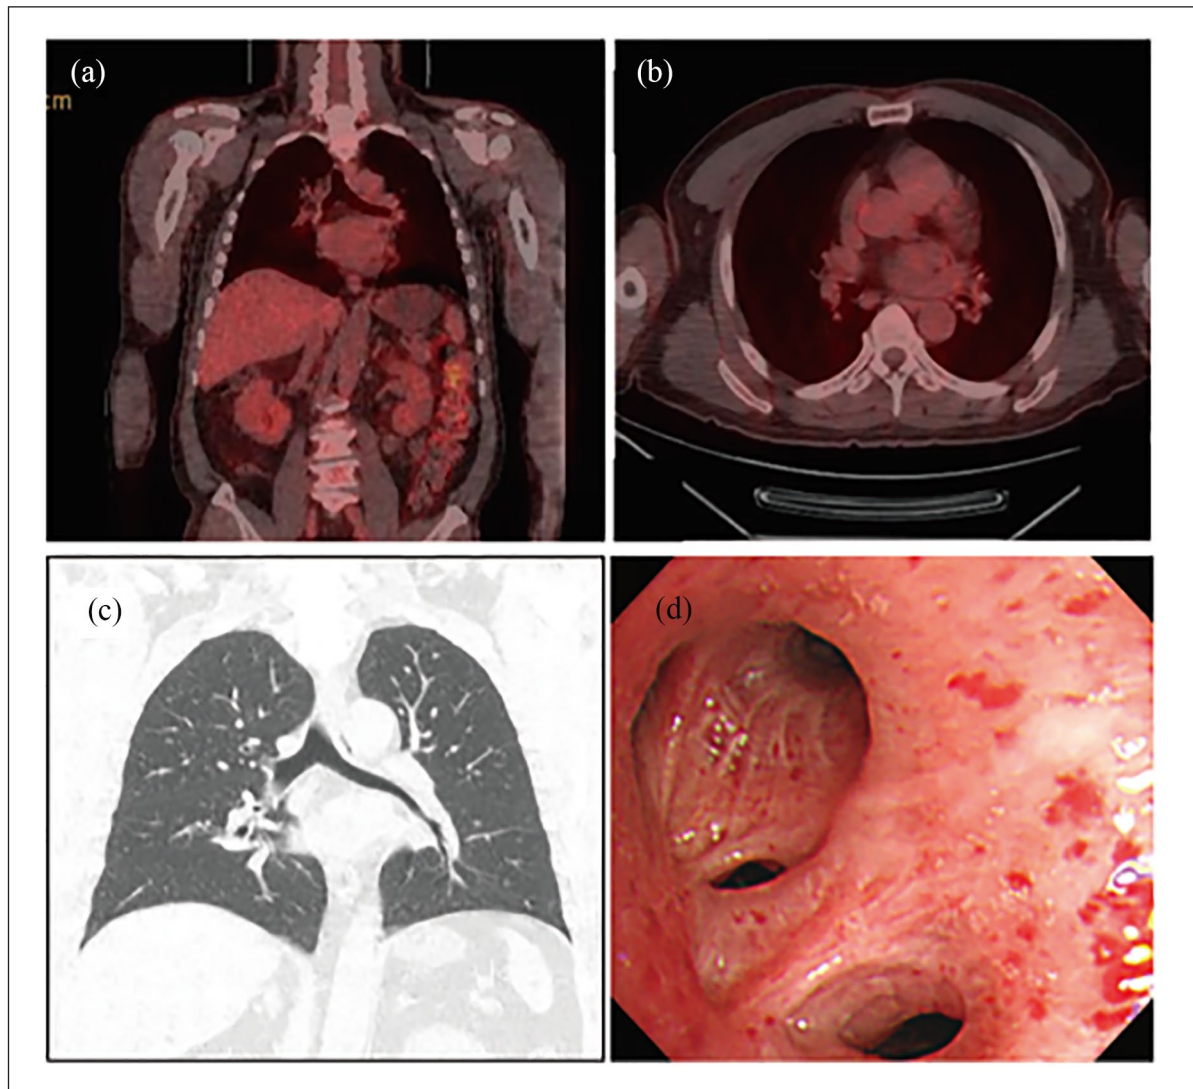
Initial PET-CT scan, last chest CT scan, and bronchoscopic finding. (a and b) Initial PET-CT scan showed no hypermetabolic lesion. (c) Last chest CT scan performed at about 4 years after initial diagnosis showed no recurrence of squamous cell cancer. (d) Last bronchoscopic finding was normal.
